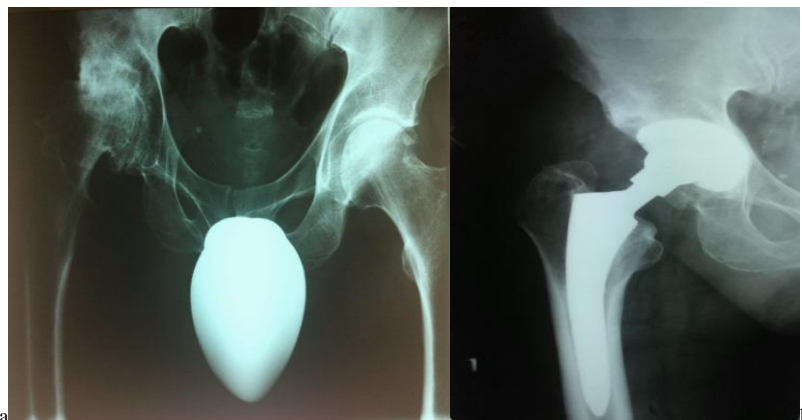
Pre-operative radiographs of 49 – year-old men with coxarthrosis (a). Post-operative radiographs after total hip arthroplasty with new femoral component (b) and after 2 years result (c, d)
